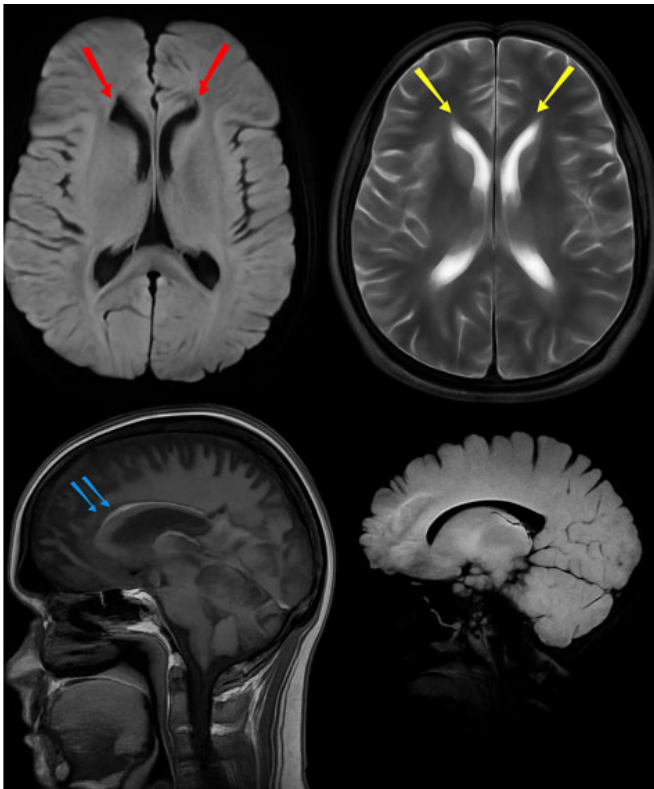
MRI Brain showing dysgenesis of the corpus callosum with severe atrophy of the rostrum, genu, and anterior body of the corpus callosum and partial atrophy of the posterior body and splenium with white matter hyperintensity in the periventricular region predominantly in the frontal regions giving rise to the classical “ear of the lynx sign.”
